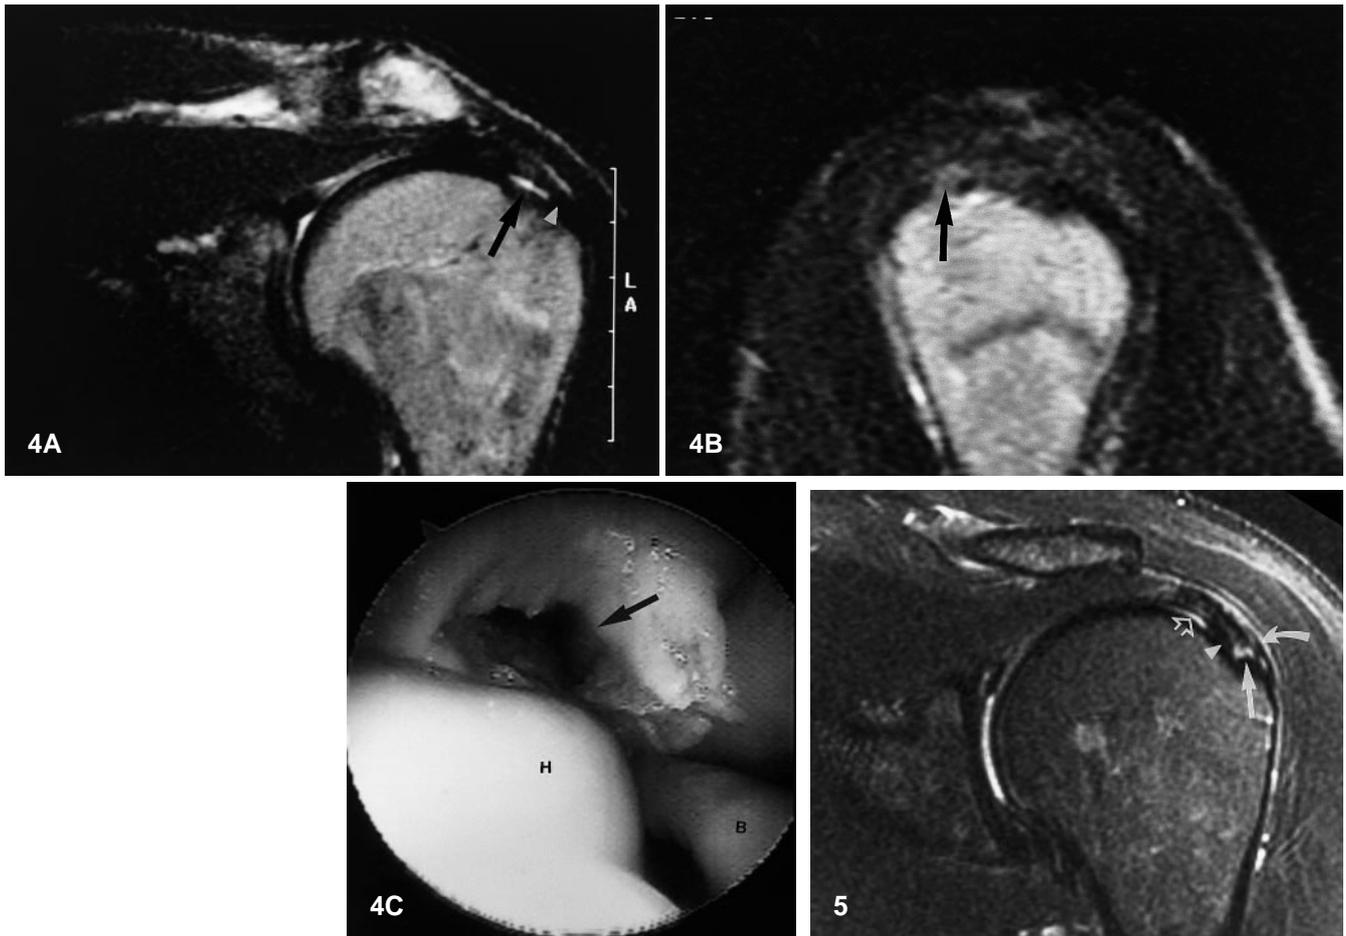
Rim-vent articular surface partial-thickness rotator cuff tear in a 32-year-old man. A Oblique coronal and B oblique sagittal spin-echo T2-weighted (2000/90) MR images show high-signal fluid (*arrow*) in the tear near the greater tuberosity, with disruption of the articular surface fibers adjacent to the insertion. Note that the bursal portion of the rotator cuff is intact to its attachment (*arrowhead*). This was correctly interpreted prospectively as an articular surface partial tear. C Arthroscopic photograph looking anterolaterally demonstrates the “rim-vent” tear (*arrow*). *H* Humeral head, *B* long head of biceps tendon
